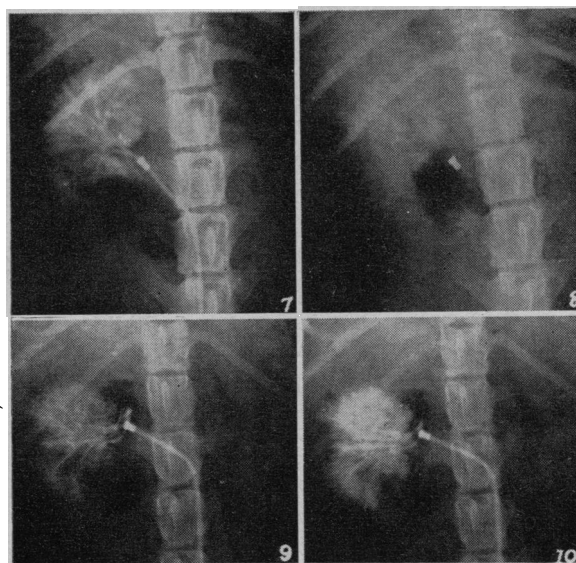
Normal arteriogram after catheterization and injection of 6 c.c. of 35% diodrast into the right renal artery. Fig. 8.—Radiography of the same kidney 10 minutes later. The metal cap in the renal artery proves that the catheter is still *in situ*. Fig. 9.—Renal arteriography of a kidney wrapped in cellophane 4 months previously (3 c.c. of 35% diodrast). Fig. 10.—Same kidney as in Fig. 9 after the injection of 6 c.c. of 35% diodrast.
